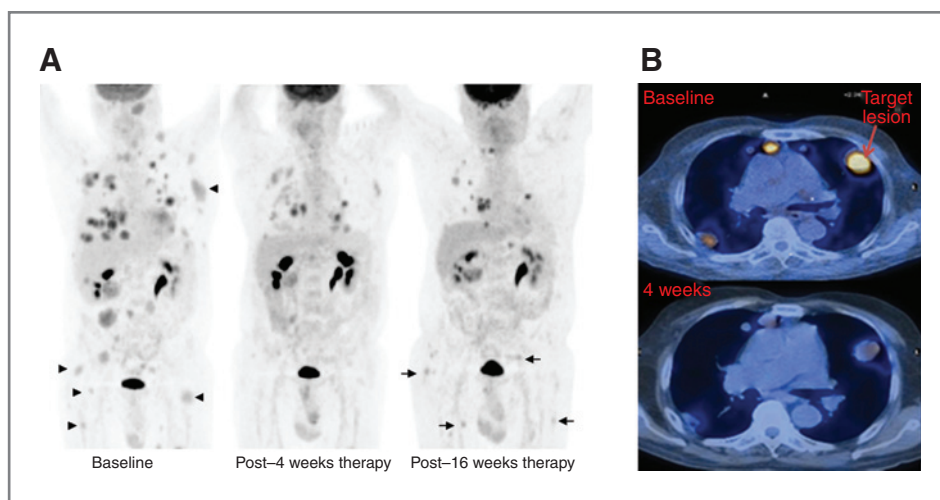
A, maximum intensity projection images of sequential whole body PET scans. Baseline scan shows widespread FDG-avid metastatic lesions including multiple muscle deposits (arrowheads). The 4-week scan shows a response in  $SUV_{max}$ . The 16-week therapy scan shows new FDG-avid muscle deposits consistent with progression. B, comparison of axial-fused PET-CT images at identical level through the chest at baseline and 4 weeks postcommencement of therapy showing a response to therapy.
